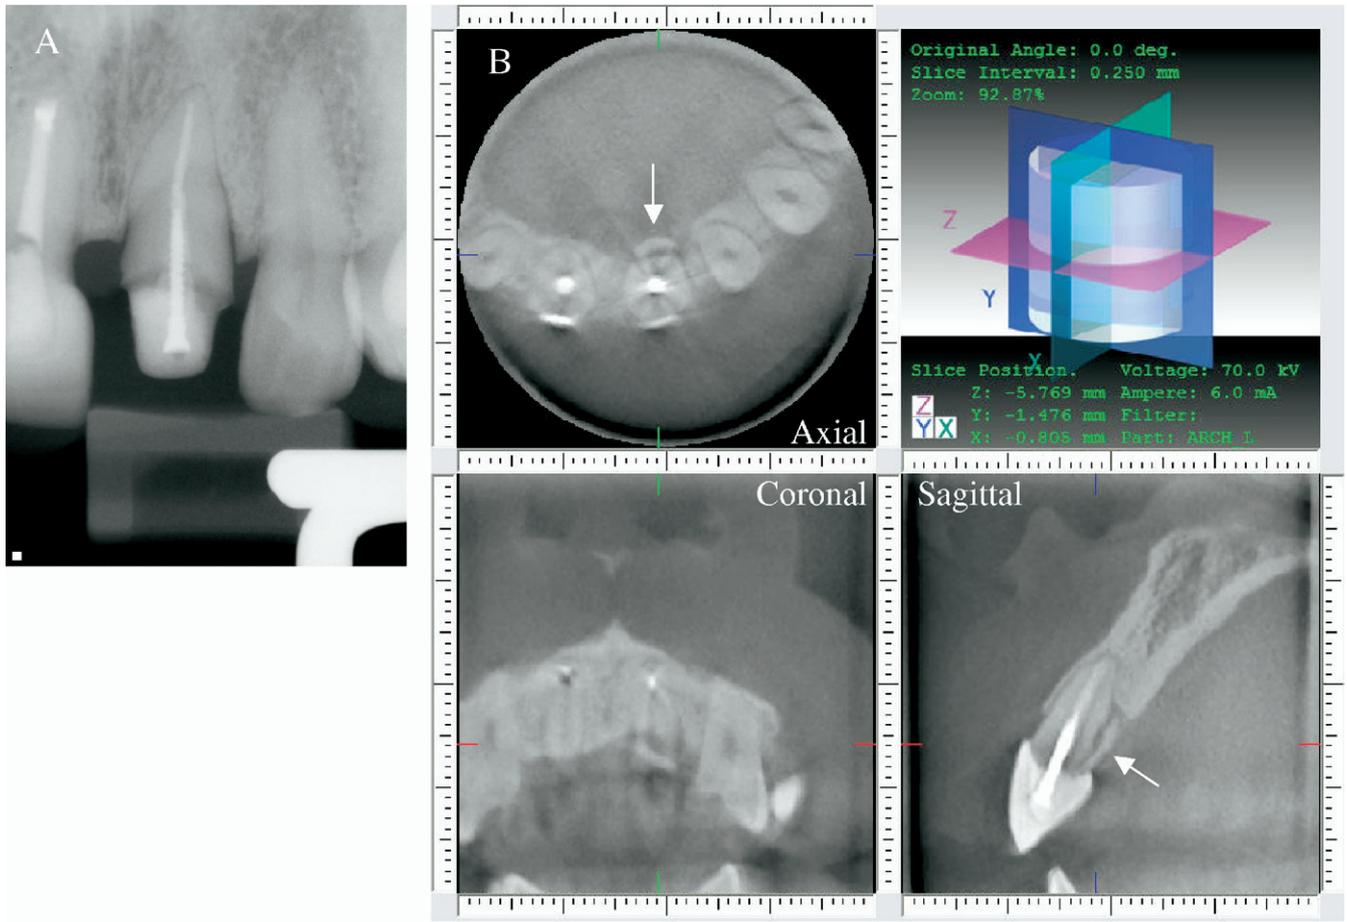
(A) Periapical radiograph of tooth #9 with its crown removed. (B) CBVT demonstrates the axial, sagittal, and coronal 2-D slices of the shearing-type crown-to-root fracture with corresponding loss of bone isolated to the lingual portion of #9.
